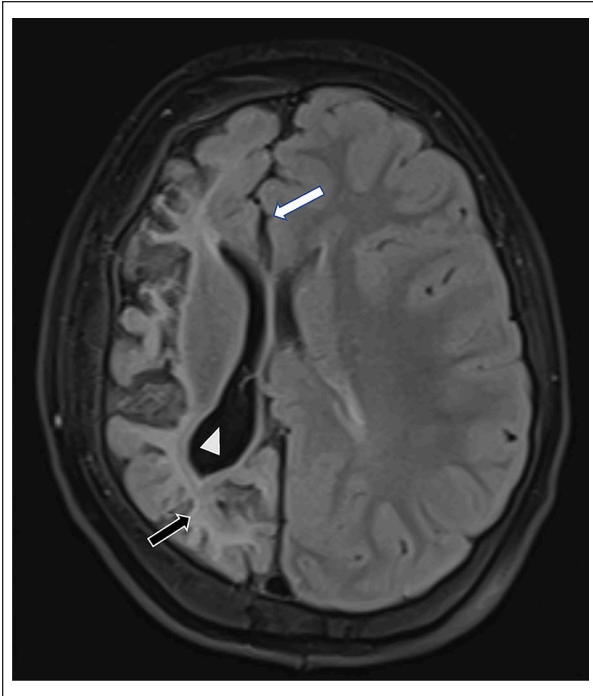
Axial FLAIR sequence showing a right hemispheric atrophy with enlargement of the right lateral ventricle (White arrow head) and a midline shift (White arrow), Hyperintensity of the subcortical white matter on the affected side (gliotic changes) (Black arrow).
